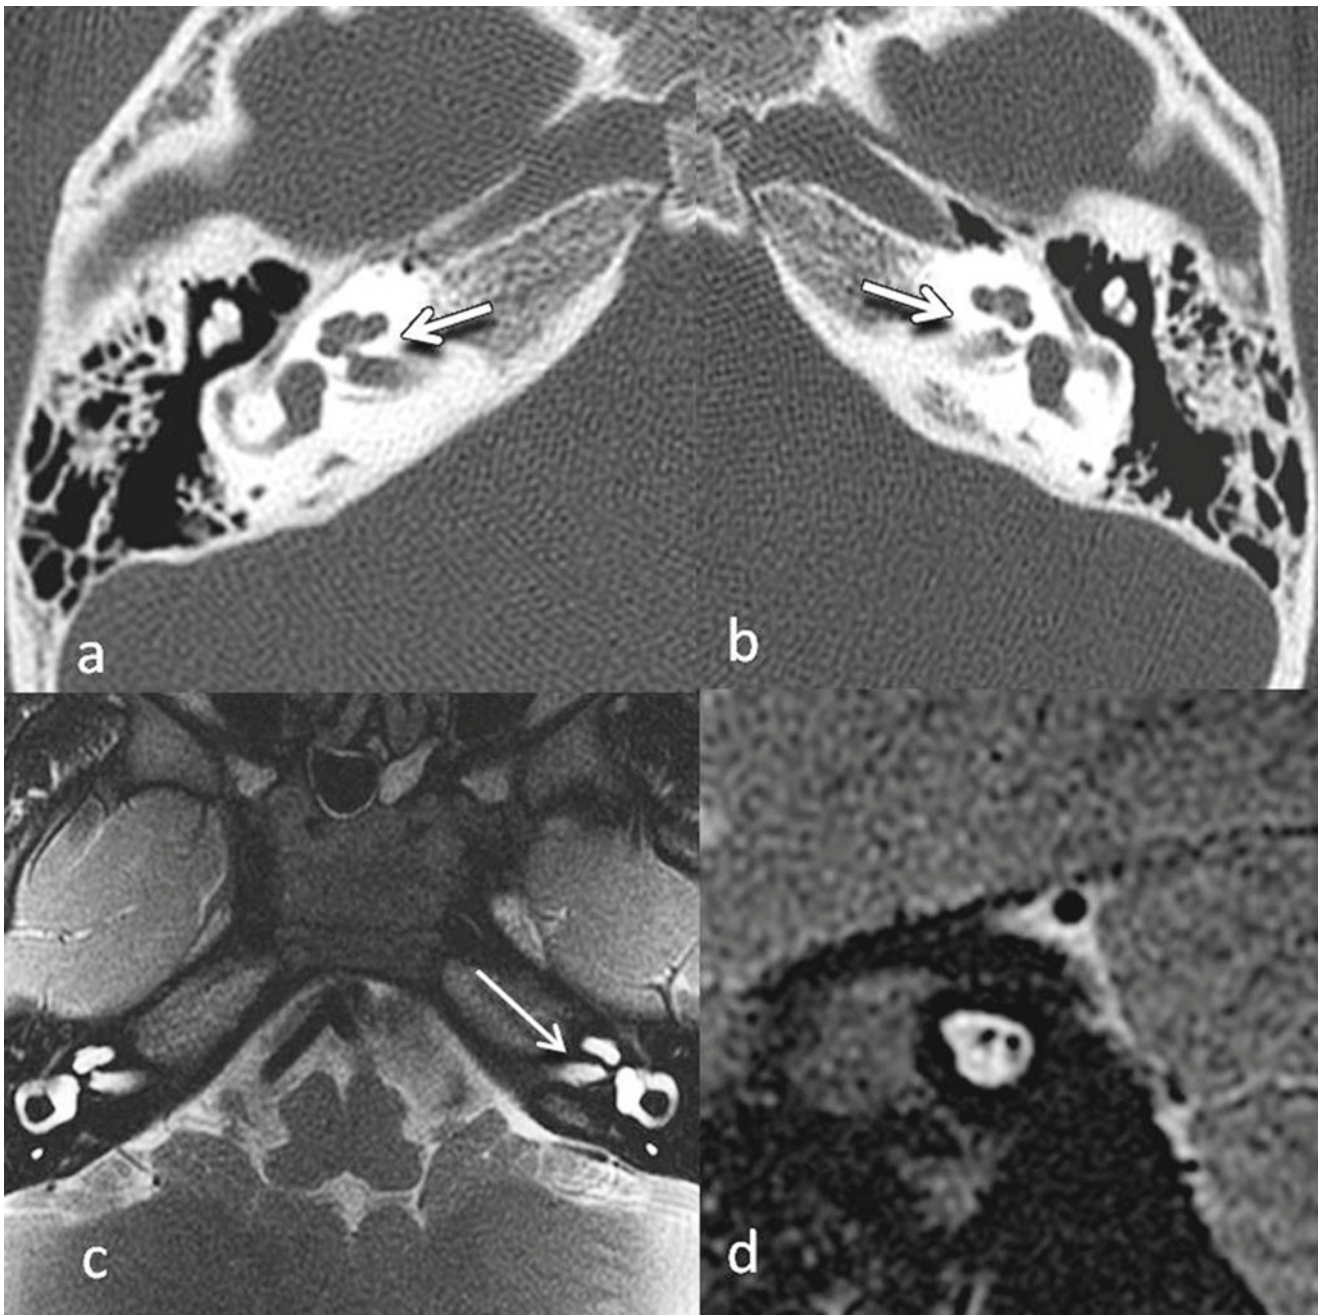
CT and MRI findings demonstrating cochlear nerve deficiency in a 3 year old child with profound bilateral sensorineural loss. Axial CT demonstrating abnormal bony canal through which cochlear nerve leaves the IAC to enter the inner ear: (a) right cochlea with moderate stenosis (*arrow*) and (b) left cochlea with very severe stenosis
